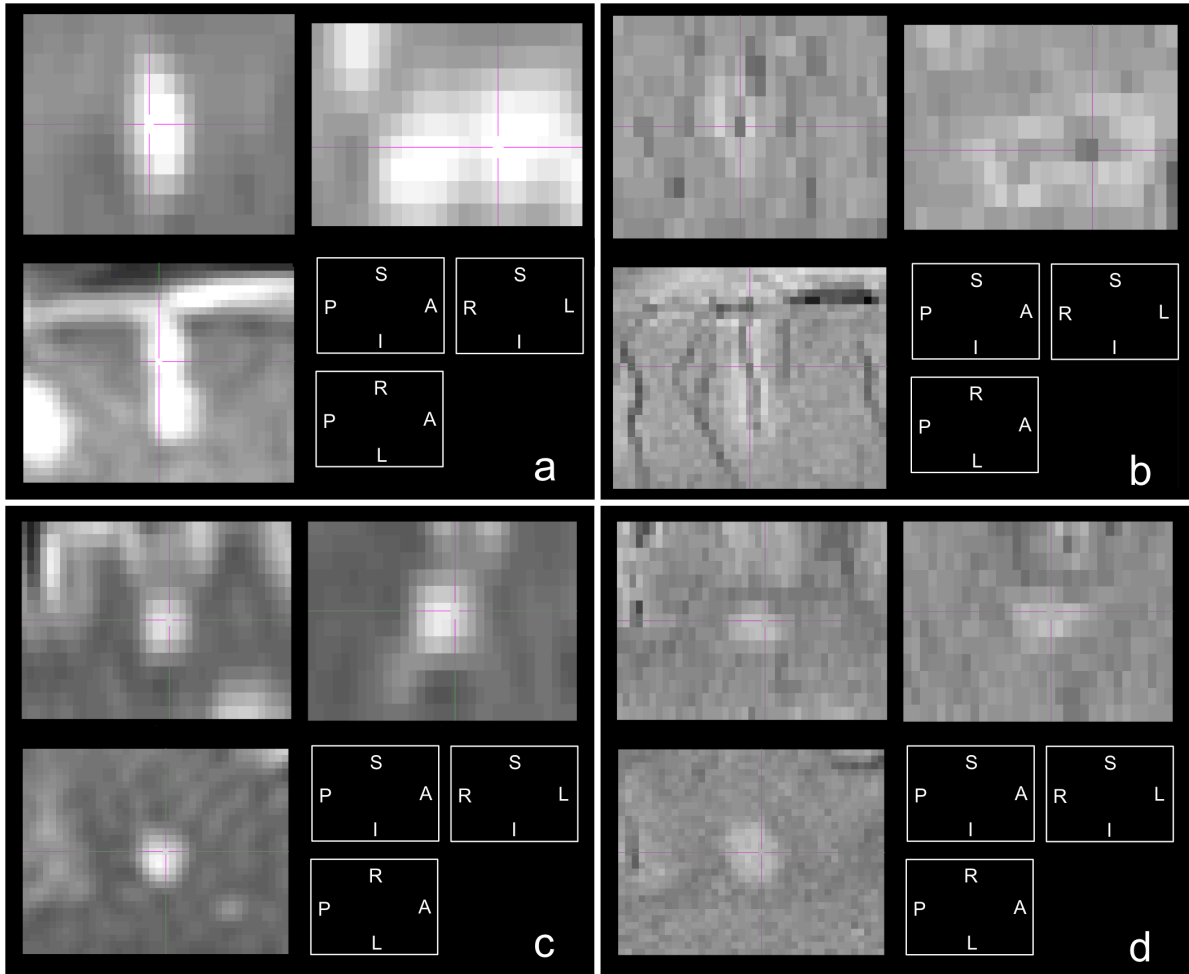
FLAIR (a,c) and multi-echo SWI (b,d) of a venocentric WMH in a patient with MS (a,b) and of a non-venocentric WMH (c,d) in a healthy control.
